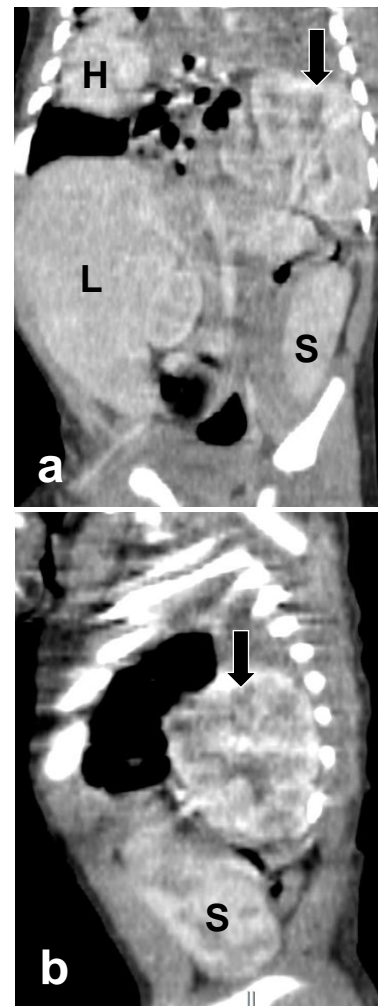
Abdominal CT scan at 14 days old. Coronal (a) and sagittal (b) images in soft tissue window setting show the liver (L) occupying most of the right hemiabdomen. The spleen (S) is seen in the lateral aspect of the left hemiabdomen and inferior to the displaced intrathoracic left kidney (arrows). Note the heart (H) is displaced to the right
